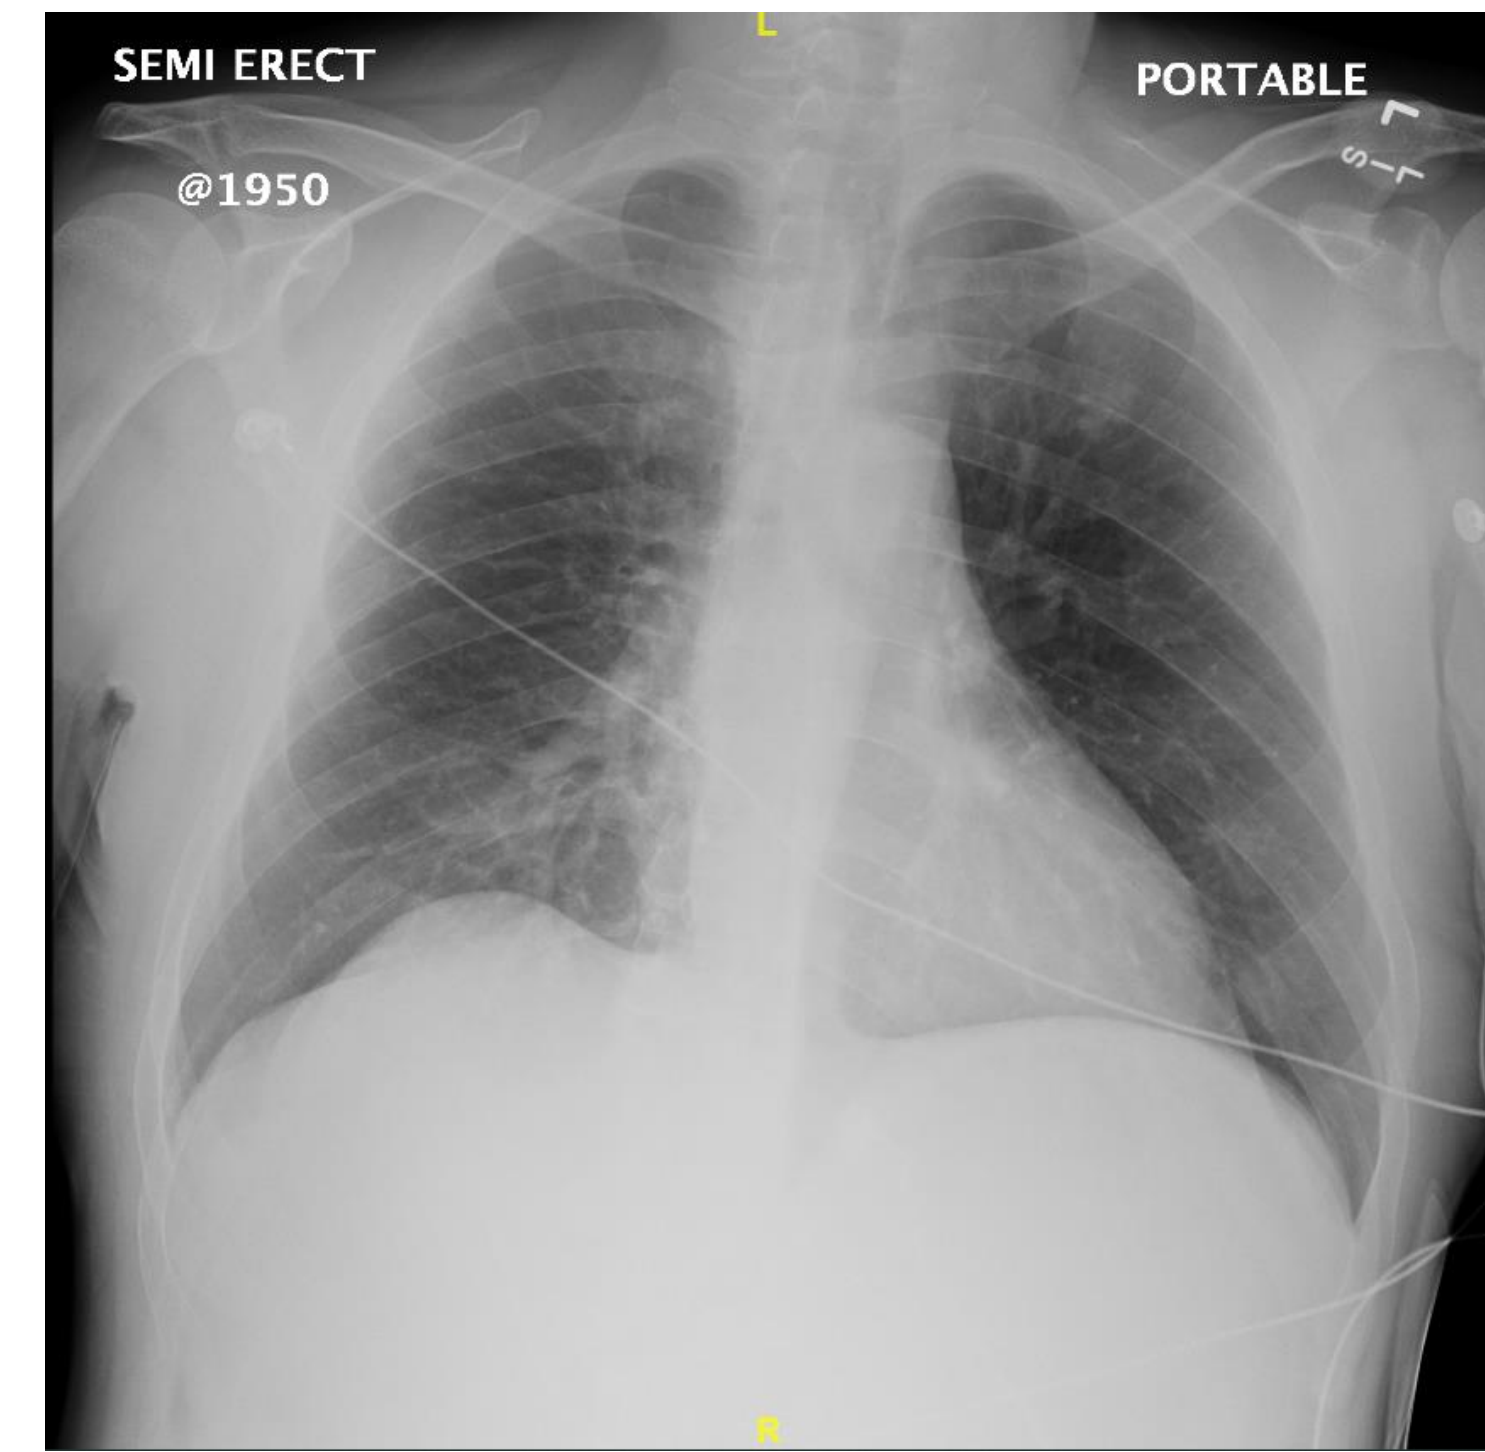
Chest x-ray on day of admission.
